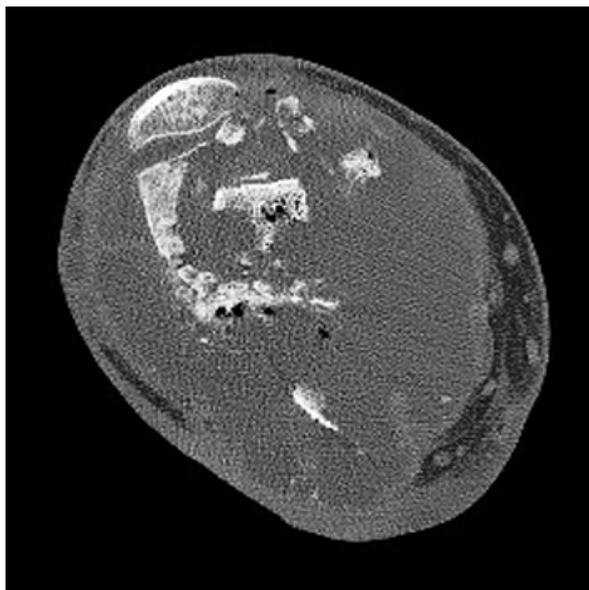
Computed tomography scan of right knee showing osteolysis with mass destruction of the knee associated with an important collection of intra and periarticular.
